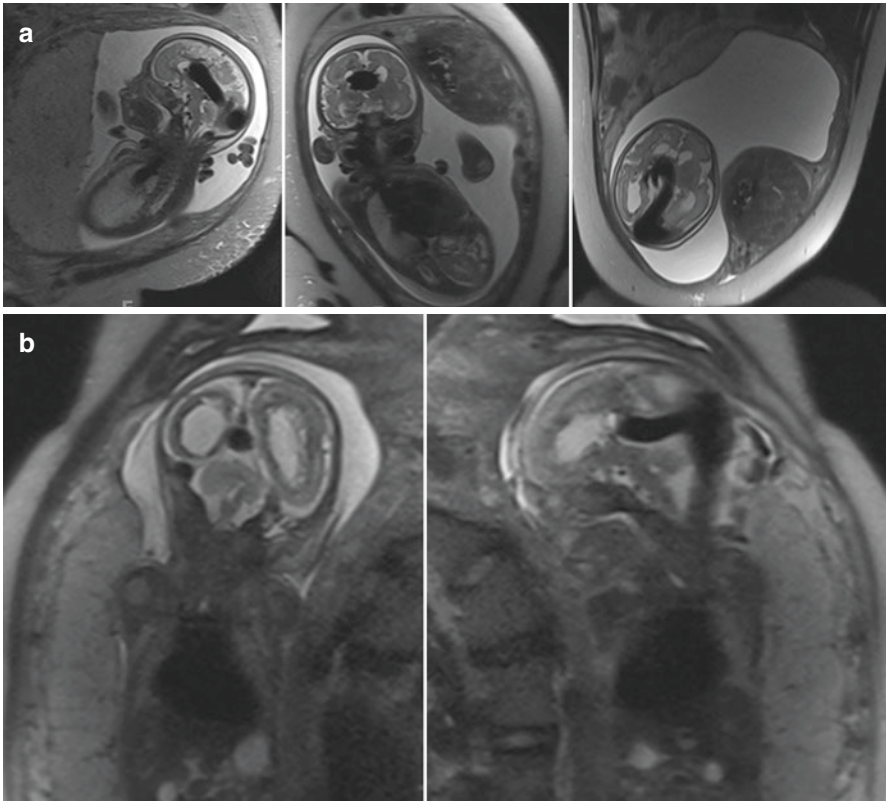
Serial fetal T2-weighted MR images of a fetus with a VGAM. On the initial MRI (a) the dilated, elongated vein is noted in typical location. First signs of periventricular leukomalacia are seen which progress (“melting brain”) on the follow up fetal MRI (b). In addition, fetal cardiomegaly and fetal hydrops with subcutaneous edema and ascites are noted
